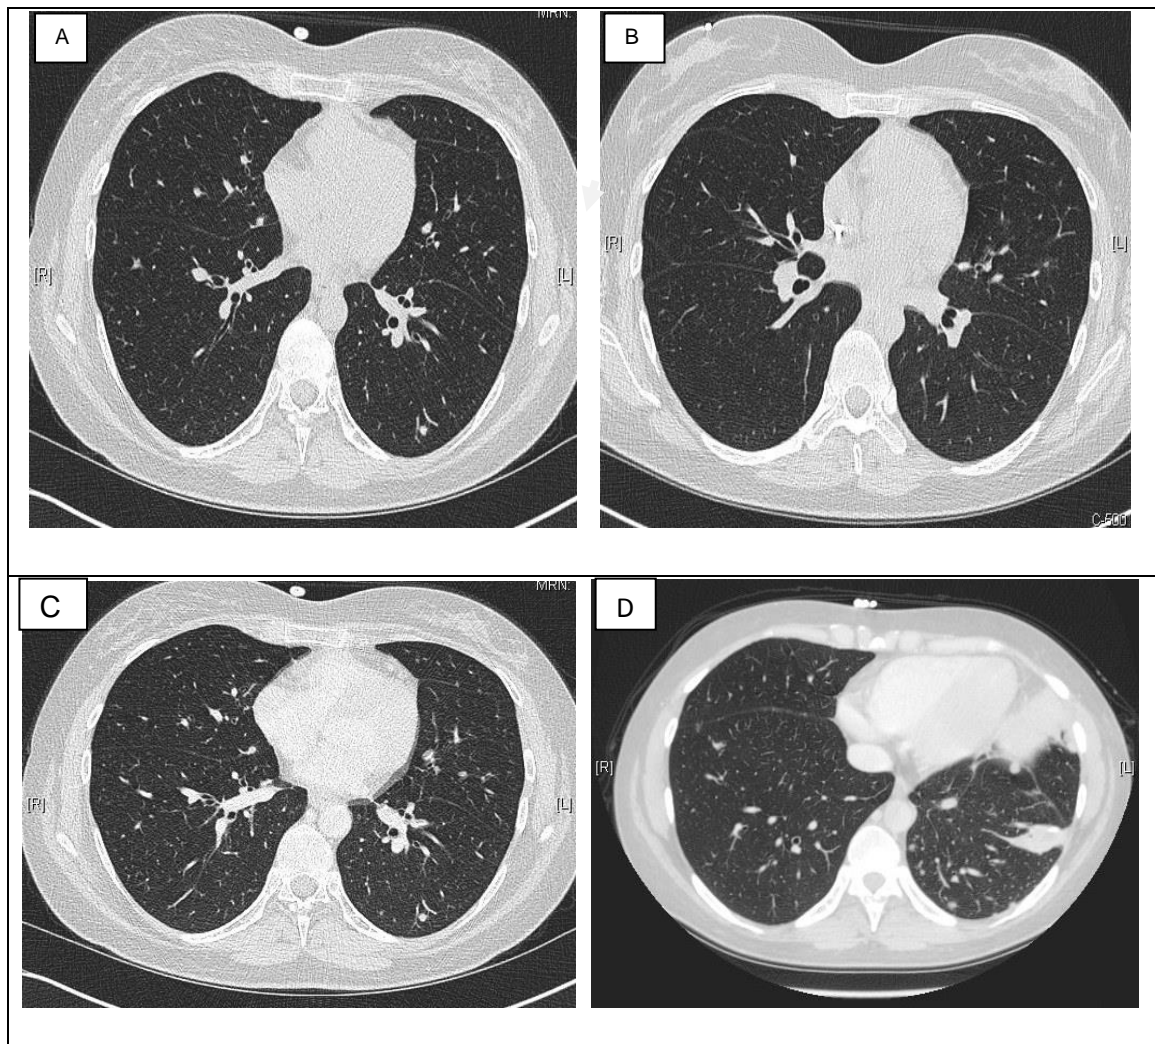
Patient 109. Baseline CT scan (A) showing a nodule with halo in the lingula. She was well and CRP was <5mg/l. No antifungal treatment was initiated. Diagnostic scan was performed 26 days after baseline scan without contrast (B) and with contrast (C) showing LLL nodules and both GM and BDG were positive. VATS biopsy confirmed invasive mould disease NOS. Second diagnostic scan (D) showing multiple nodules. Lung biopsy showed PTLD.
